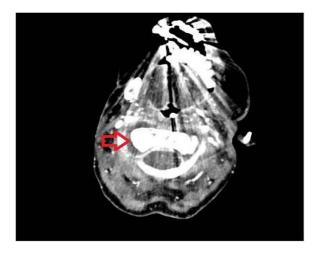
Computed tomogram, axial view of C1, showing collection with epidural extension.
